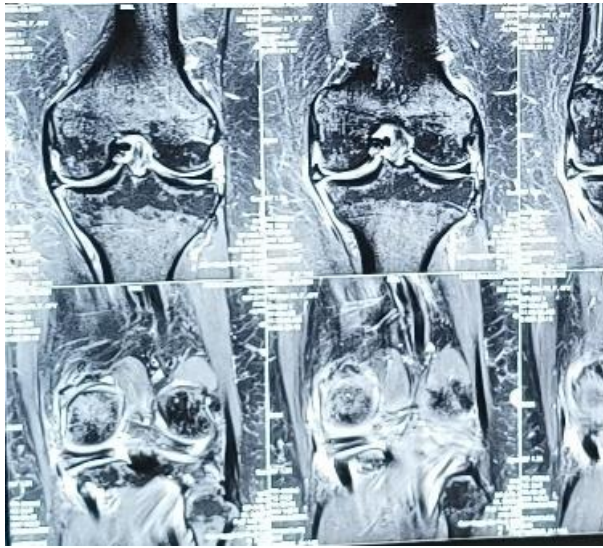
MRI showing medial meniscus root tear with extrusion of meniscus.
